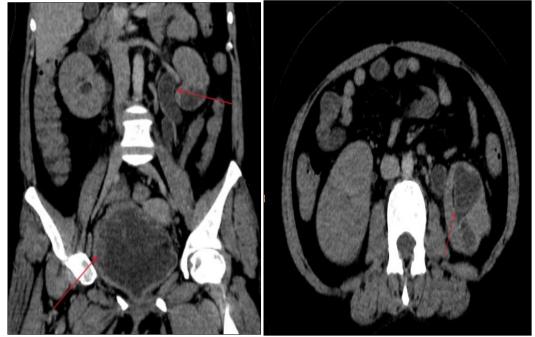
CT scan (axial and coronal sections) of moderate bilateral ureterohydronephrosis, with circumferential irregular parietal thickening of the bladder and walls of the ureteral and left caliceal cavities.
